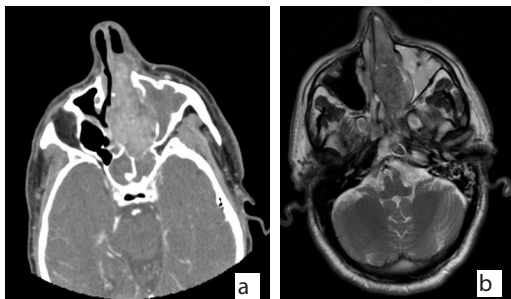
The mass filling the entire left nasal cavity (a. CT and b. MRI of face).
